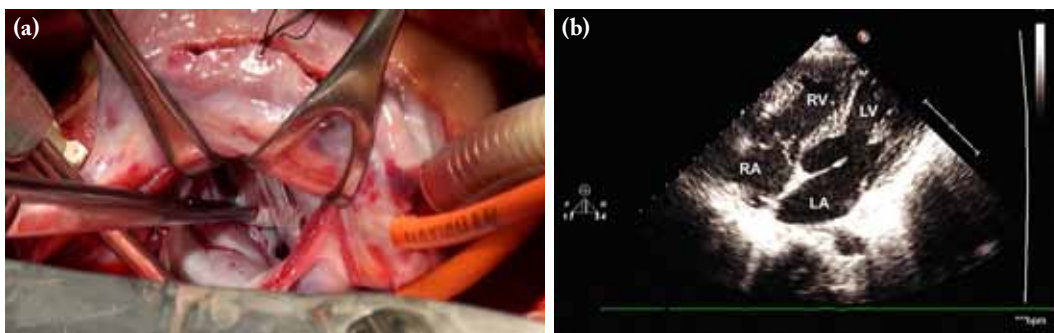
Surgical procedure image and post operative echocardiogram showing. (a) An intraoperative view obtained from the surgeon's side, showing muscle tissue in the left ventricle with fibrosis over, producing double-chambered ventricle. (b) A postoperative transthoracic echocardiogram view showing a widely opened left ventricular cavity.
